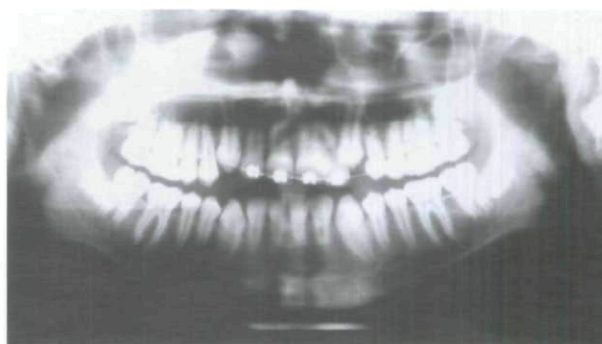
Panoramic radiograph showing the force-erupted maxillary left central incisor.
